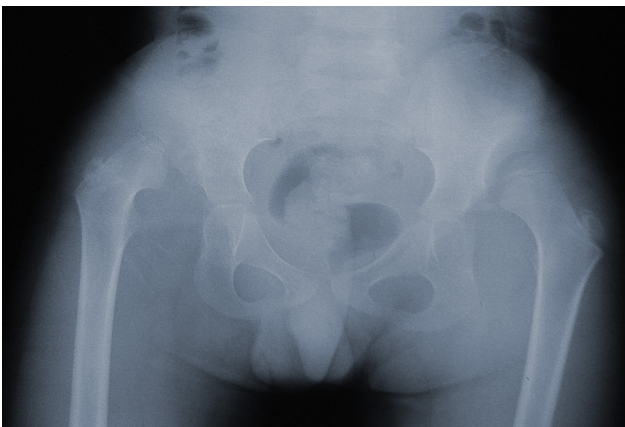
Standing anteroposterior radiograph showing the pelvis before surgery.
